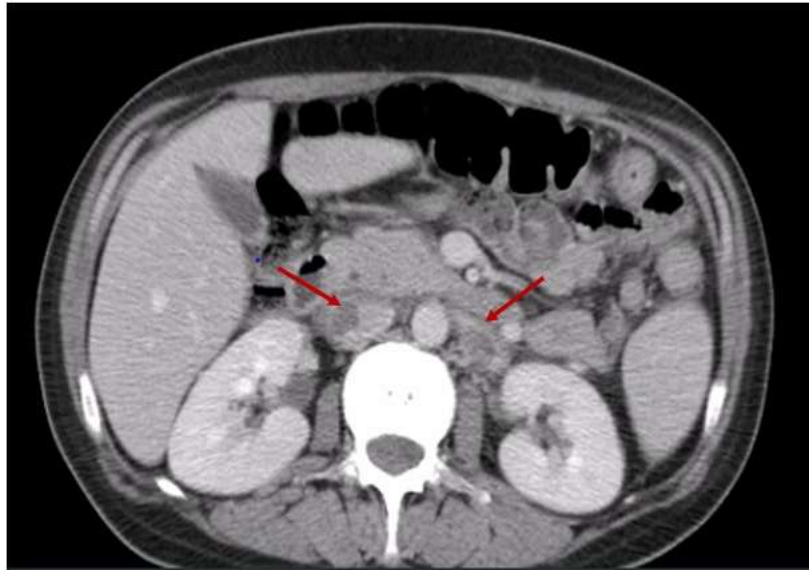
Abdominal CT scan (axial view, contrast-enhanced) showing bilateral ovarian thrombosis with an endoluminal thrombus appearing as a hypodense filling defect (red arrows). Radiology Department, Mother-Child Unit, CHU Hassan II, Fes.
